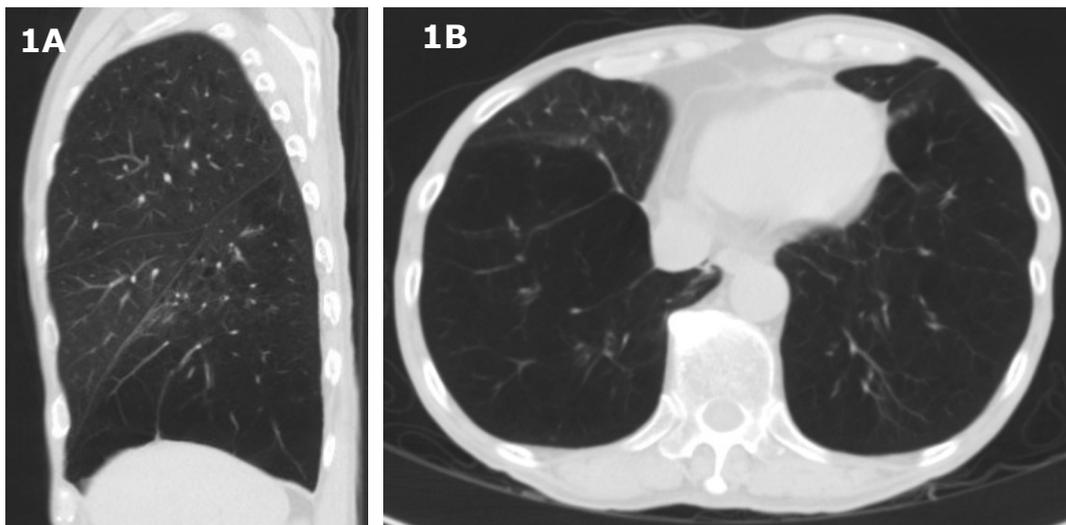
HRCT Thorax right sagittal view (Figure 1A) and axial view (Figure 1B) showing heterogenous emphysema with lower lobe predominance and complete fissures. (Please click on image to enlarge)
